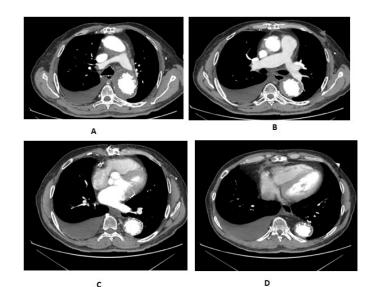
Contrast enhanced computed tomography performed after the surgical intervention.
